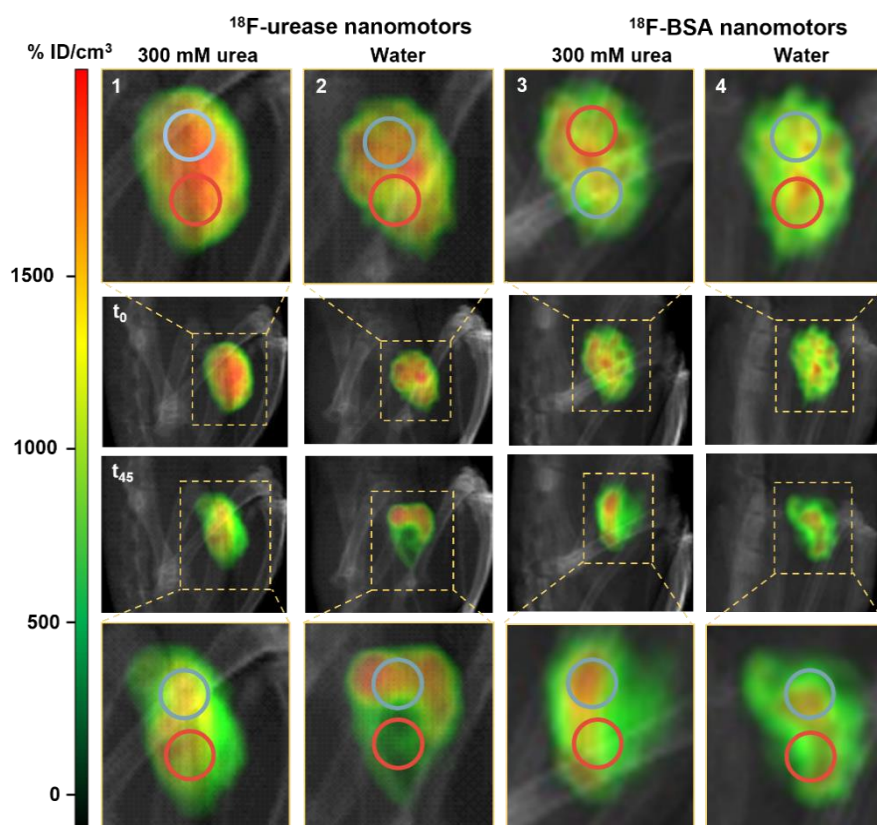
PET-CT images (maximum intensity projections) obtained at different time points after the intravesical instillation of ^{18}F -urease nanomotors in urea (1) and water (2), and control ^{18}F -BSA nanomotors in urea (3) and water (4).
